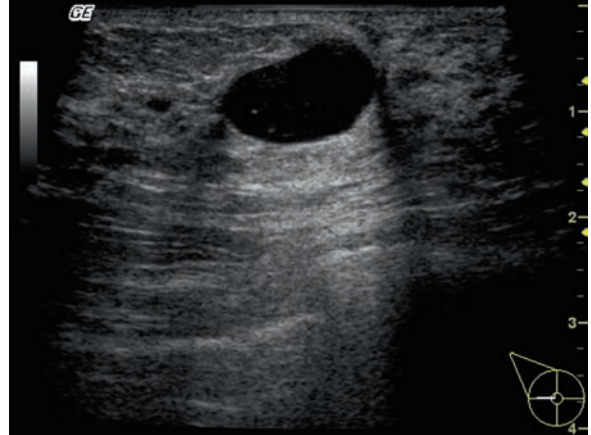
Ultrasound of a breast cyst: note the smooth outline, fluid filled lesion
